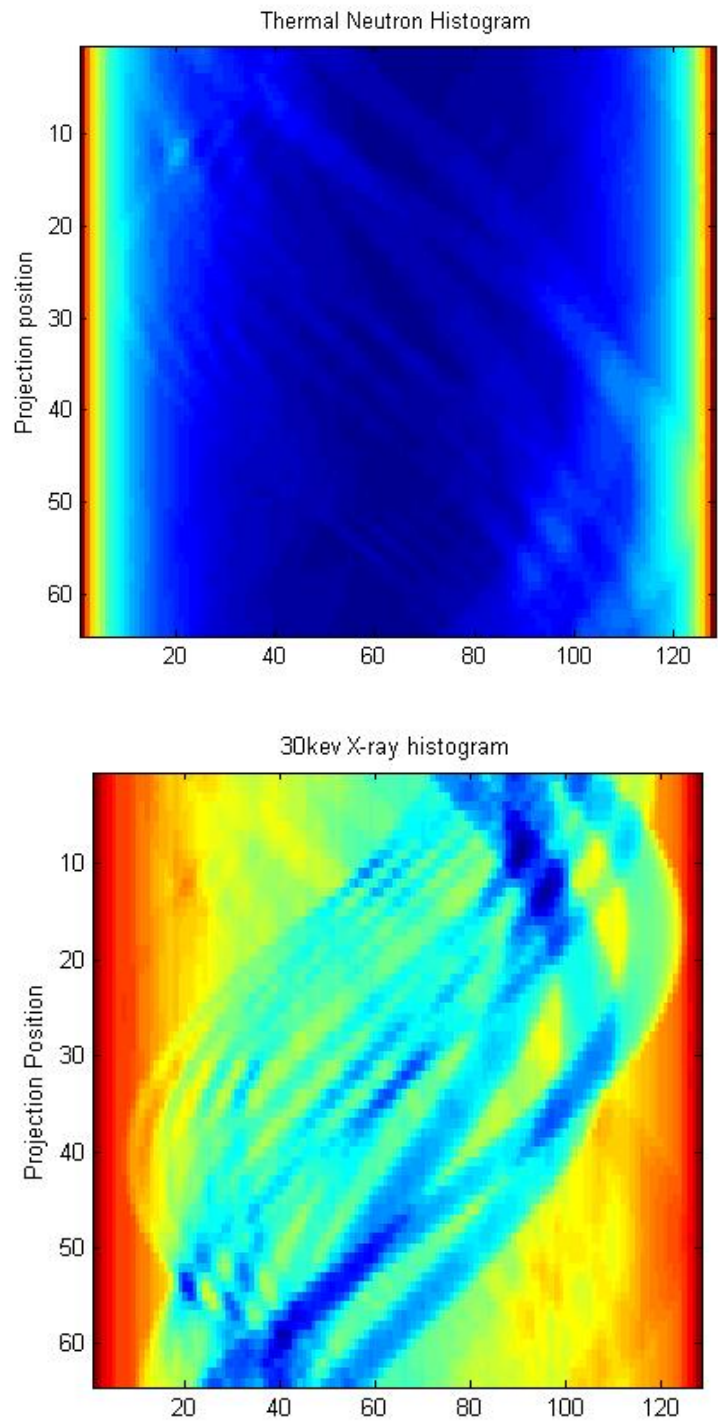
Sinogram for Neutron and X-ray Tomography
